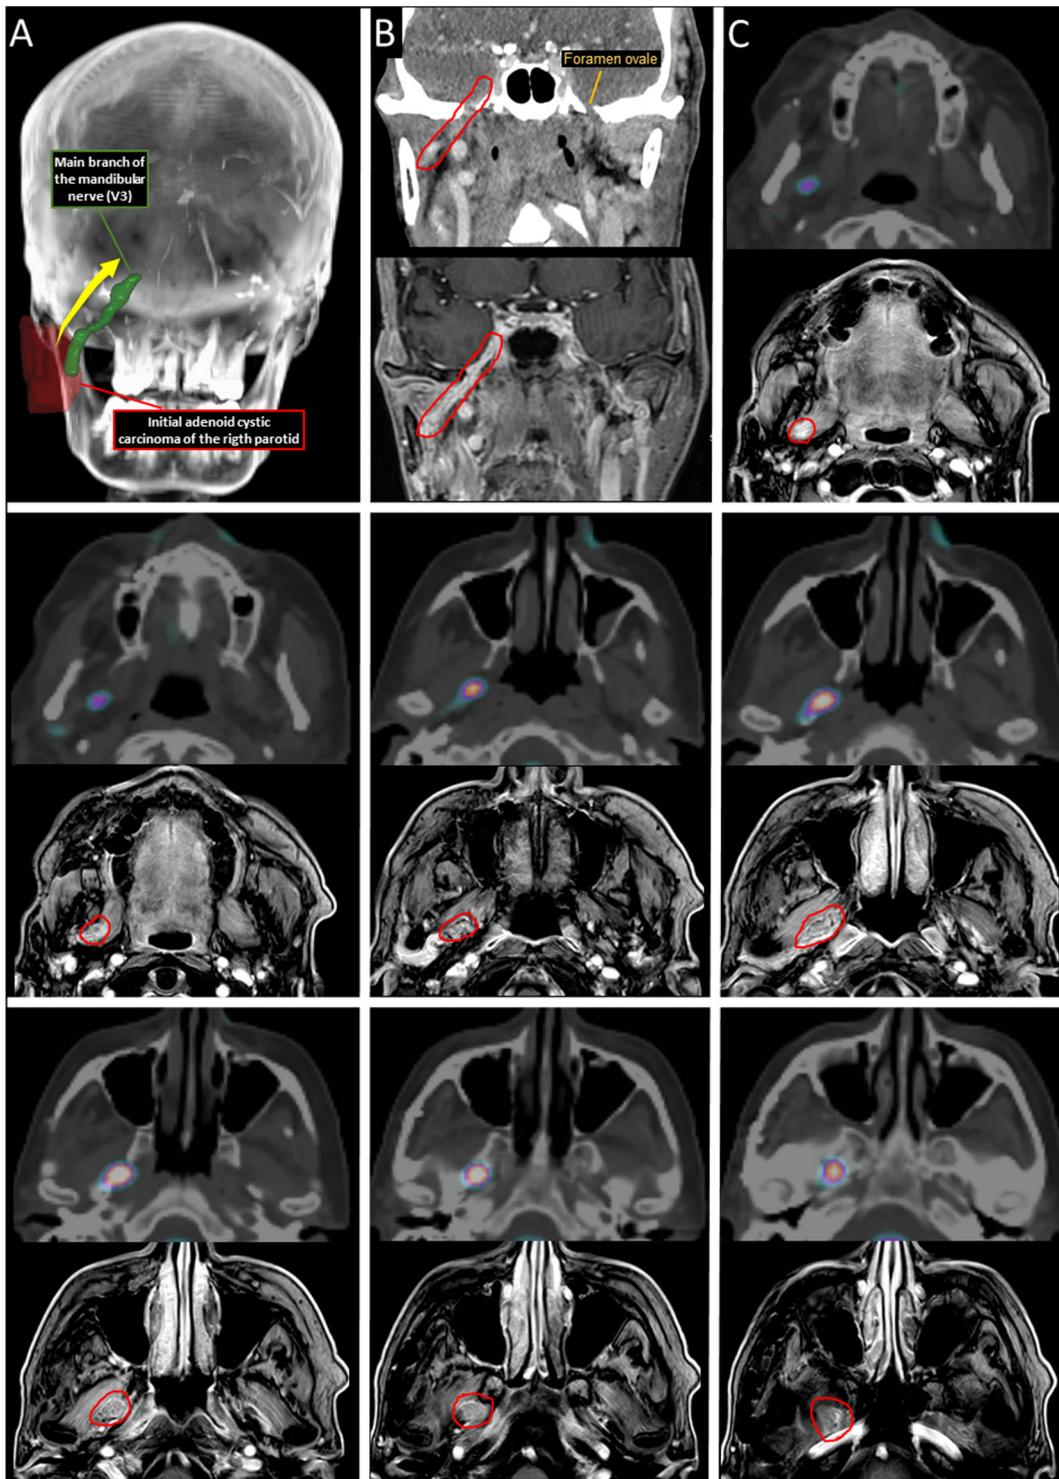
Recurrence of an adenoid cystic carcinoma of the right parotid as a macroscopic PNI of the main branch of the mandibular nerve (V3). (A) 3D overview of the extension retrograde pathway (yellow arrow) along the main branch of the mandibular nerve (V3). (B) Coronal views and (C). Axial views of both ^{18}F -FDG-PET-CT and corresponding post Gado T1-weighted MRI of the nerve extension pathway from the bottom-up. Enhancement along the main branch of the mandibular nerve is delineated in red on MRI images. Abbreviations. PNI: perineural invasion; CT: computed tomography; Gado: gadolinium; MRI (magnetic resonance imaging).
